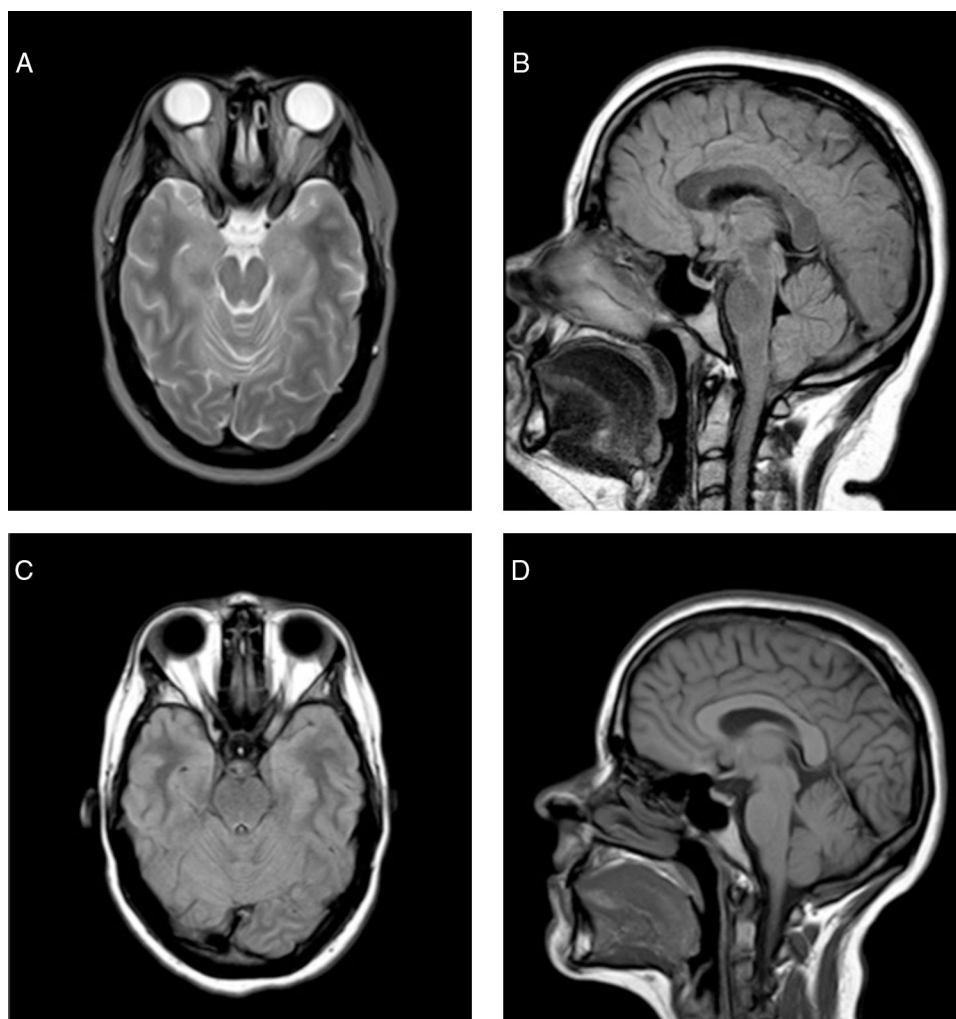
Baseline brain MRI: (A) Axial T2-weighted sequence, showing ectasia of the optical nerve sheath, with prominence of both optic discs with signs of IIH. (B) Sagittal FLAIR sequence, showing the partially empty sella turcica. The cerebellar tonsils are mildly herniated, reaching the level of the foramen magnum. Brain MR image obtained 6 months after bariatric surgery. (C) Axial FLAIR sequence, showing resolution of the orbital findings. (D) Sagittal T1-weighted sequence, showing slight retraction of cerebellar tonsils in comparison with the previous study.
